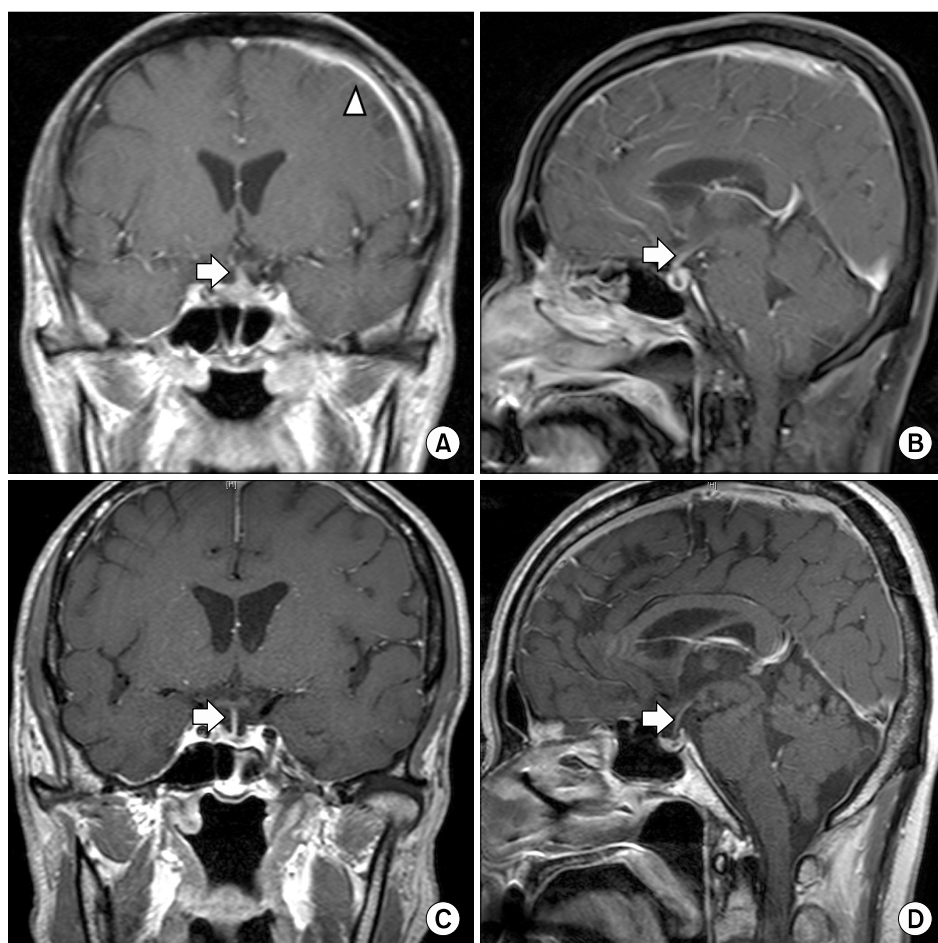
(A, B) Baseline brain magnetic resonance imaging (MRI) of T1 weighted image with contrast showing thickening and enhancement of pituitary stalk (arrows). Leptomeningeal and pachymeningeal involvement of left hemisphere are also seen (arrow head). (C, D) Follow-up MRI shows resolution of pituitary stalk thickening and enhancement (arrows), as well as pachymeningeal enhancement.
